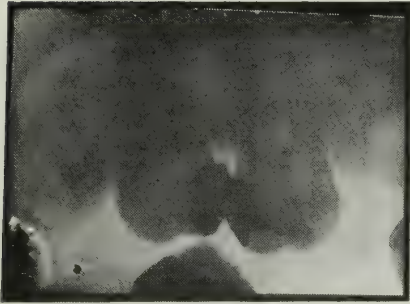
A condition around a superior lateral, exuding of pus from the gingival margins, diagnosed as pyorrhœa, which this radiograph shows to be an abscess. Note also the pyorrhœal condition of the central incisor. If the lateral had been the only tooth involved it would have been diagnosed as an abscess undoubtedly, but as there were several teeth exhibiting pus pockets, it was natural to class this tooth with them until proven definitely by radiography.
